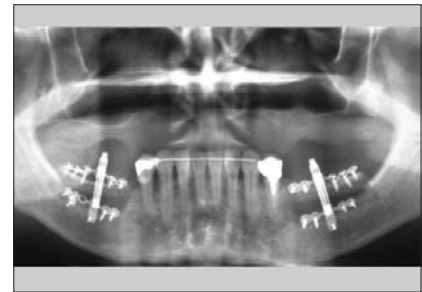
Panoramic radiograph showing moderate saddle defect.
